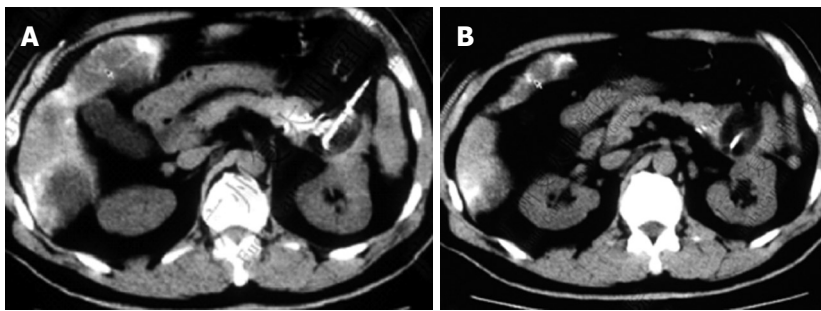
CT scan in case 4. A: Before treatment; B: Eight months after treatment.
